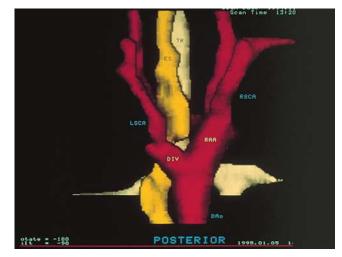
Posterior view of a three-dimensional reconstruction of an axial MRI scan of a right aortic arch with an anomalous left subclavian artery. Note the close proximity of the anomalous subclavian artery to the esophagus and its potential obstruction of the esophagus. ES, esophagus (yellow); DAo, descending aorta (red); DIV, diverticulum; LSCA and RSCA, left and right subclavian artery, respectively (red); RAA, right aortic arch (red); TR, trachea (white). (*Courtesy Beverly Newman, MD, Children's Hospital of Pittsburgh, Pa.*)
